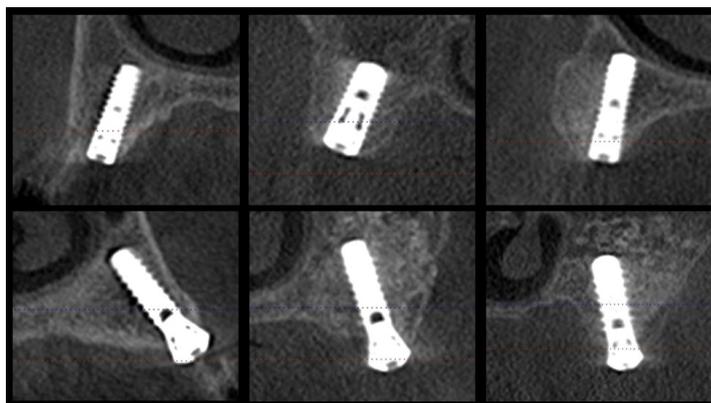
CBCT scan 4 months after implant placement.
